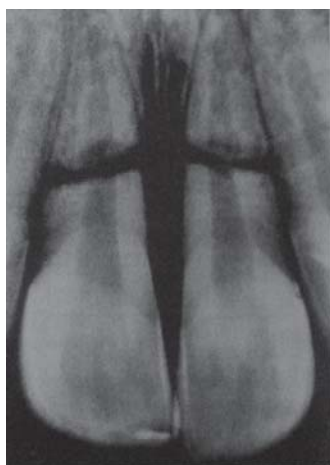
Radiograph showing horizontal root fracture (Ellis Class 6/WHO N502.53)
